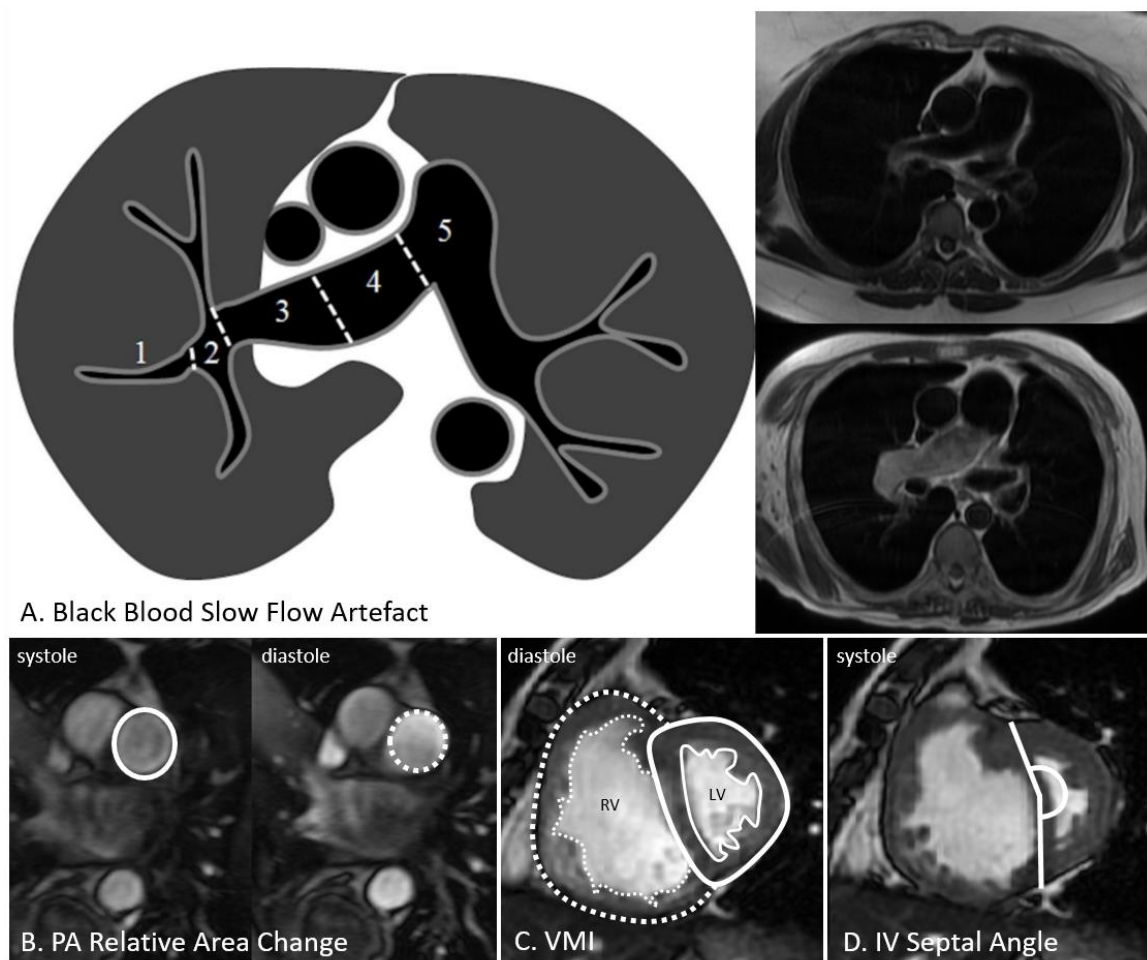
Multi-figure showing the MRI metrics used in this chapter.
